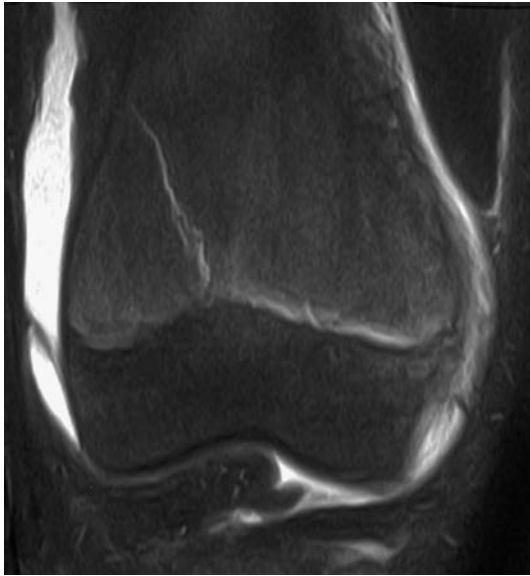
MRI of patient after injury with normal radiographs. MRI clearly documents the presence of a Salter–Harris type II fracture of the distal femur.
